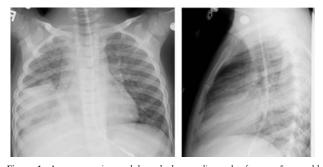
Anteroposterior and lateral chest radiographs from a 5-year-old child with pneumococcal pneumonia. Dense consolidation is apparent in the right middle and lower lobes. Blood culture was positive for *Streptococcus pneumoniae*.
